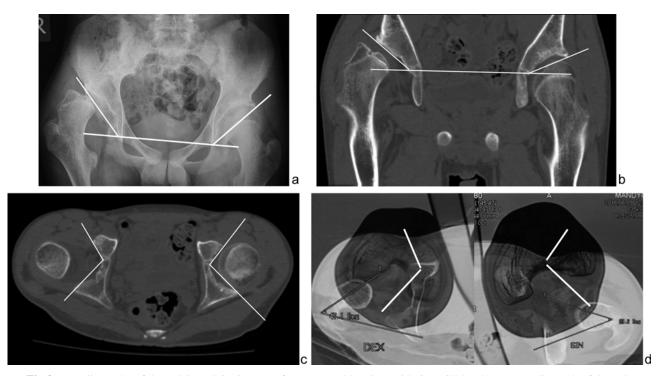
AP radiographs of the pelvis and CT images of a 15-year-old patient with GMFCS level IV: $\bf a$ – radiograph of the pelvis, right-sided dislocation: Sharp's angle is 52 ° (right) and 46 ° (left); $\bf b$ – frontal section: AI is 41 ° on the right and 25° on the left; $\bf c$ – axial section: axial acetabular index of 109° on the right and 96° on the left; $\bf d$ – angles of anteversion of the femoral necks (right 47°, left 39°)
